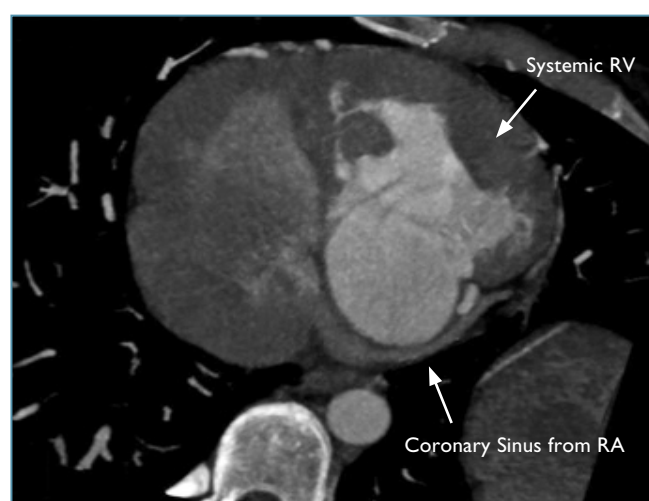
CT scan to delineate the anatomy of the coronary sinus in a patient with CCTGA – prior to planning a transvenous biventricular pacemaker.
